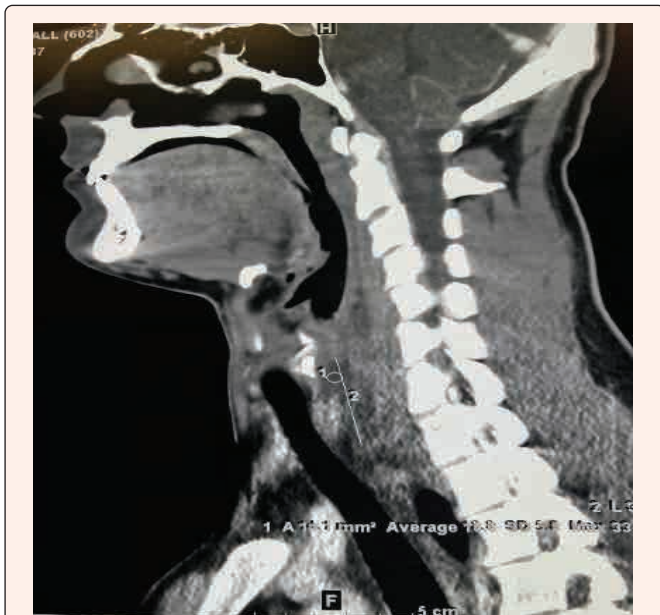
Computerized Tomography (CT) neck was performed showing 3.2 x 1.9 cm x 7 cm Retro Pharyngeal Abscess (RPA) in craniocaudal length from C5 to T2, together with mediastinitis throughout the superior mediastinal fat. The glottis and trachea are displaced without compression.
